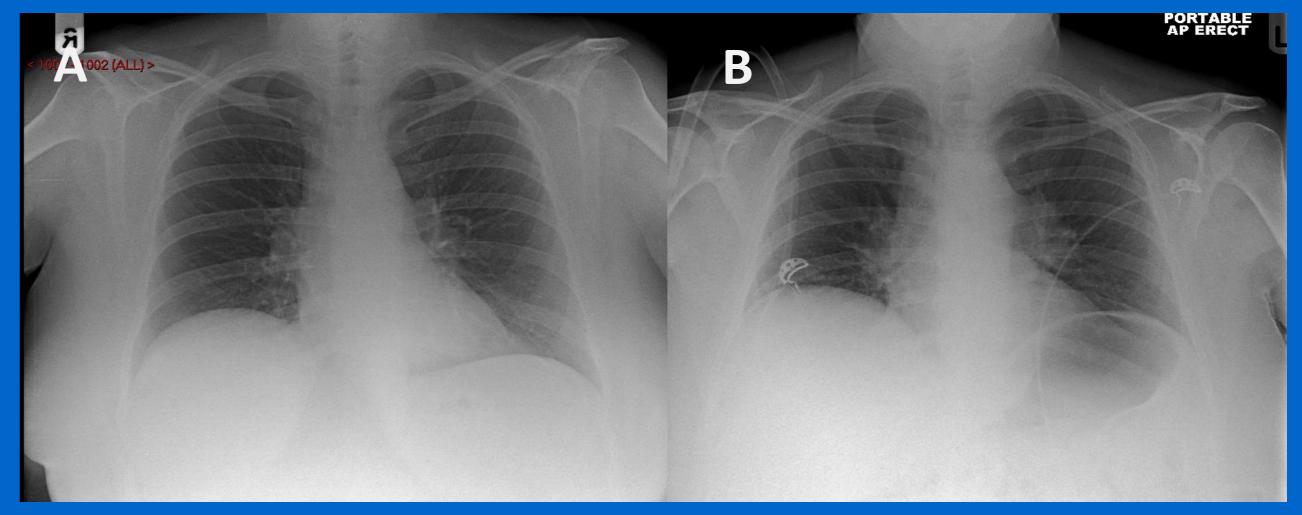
Chest radiograph prior to treatment of CD (A) and afterward (B)
